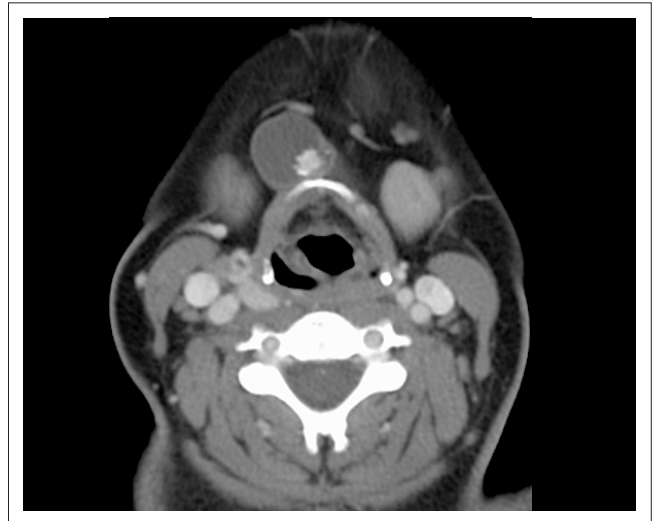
Axial CT scan image at level of hyoid bone.
